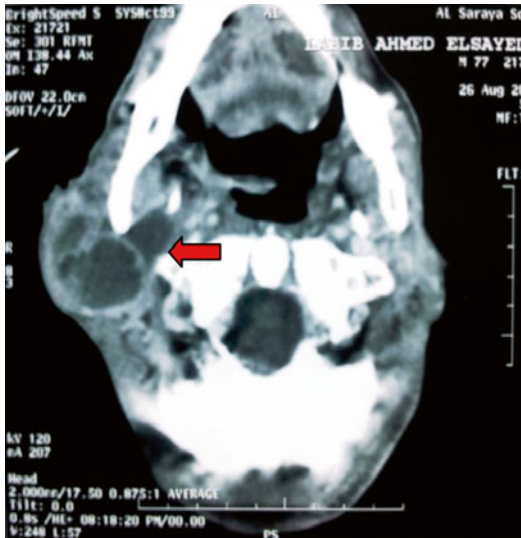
CT scan showing extension of the PA to involve the deep lobe of the parotid gland (*red arrow*)
